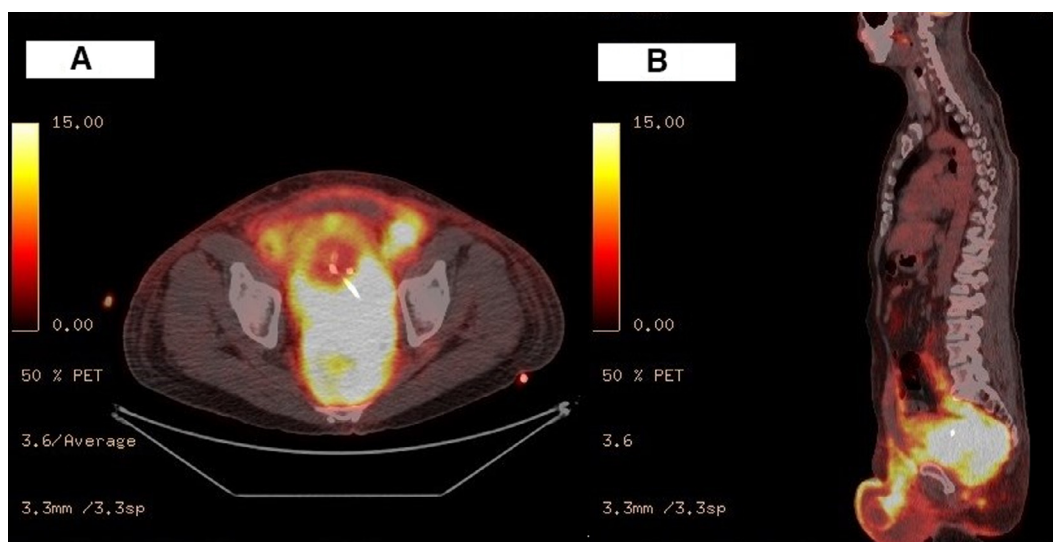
PET/CT evaluation with ^{18}F -fluorodeoxyglucose, showing in axial (A) and sagittal (B) planes high FDG uptake in pathological tissue located in pelvis.
